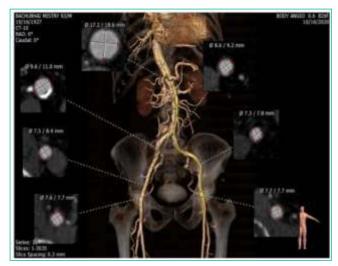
CT image showing various dimensions of the peripheral arteries
